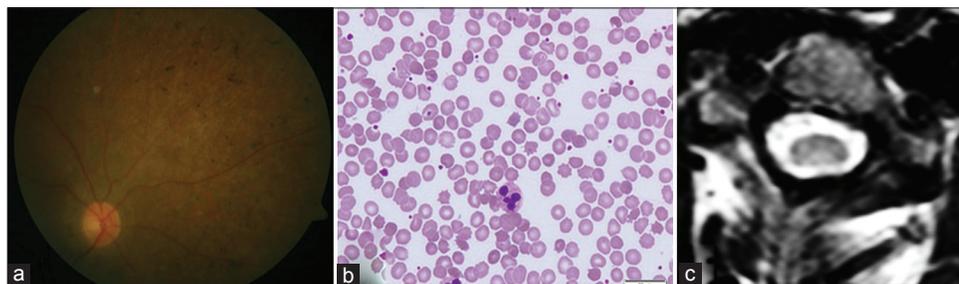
(a) Fundus photograph of the patient shows tapeto-retinal degeneration with bone-corpuscle like pigment dispersion in the mid-periphery of the retina and minimal attenuation of retinal arterioles, suggestive of an atypical form of RP, (b) Peripheral smear shows numerous acanthocytes, (c) Axial T2W magnetic resonance imaging of the cervical spine shows hyperintense signals in the dorsal columns
